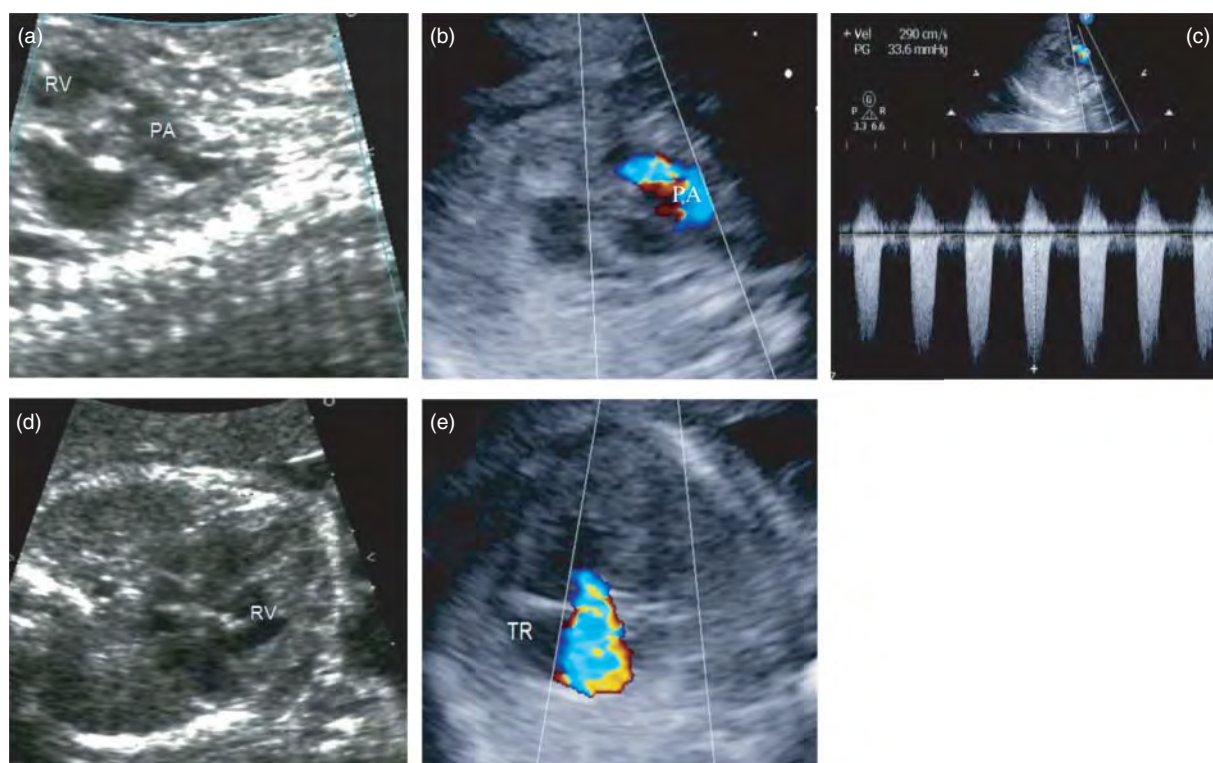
Progression of right ventricular outflow tract (RVOT) obstruction. (a) At 20 weeks, the pulmonary valve is doming and thickened. The right ventricle (RV) is mildly hypertrophied with normal systolic function. (b) Color flow mapping revealed turbulence at the level of the valve. (c) Peak gradient is 34 mmHg. (d) At 24 weeks, there is moderate RV hypertrophy and hypoplasia, with severe tricuspid regurgitation (TR) by color flow Doppler (e), predicting a suprasystemic right ventricular pressure (RVP). PA, pulmonary artery.
